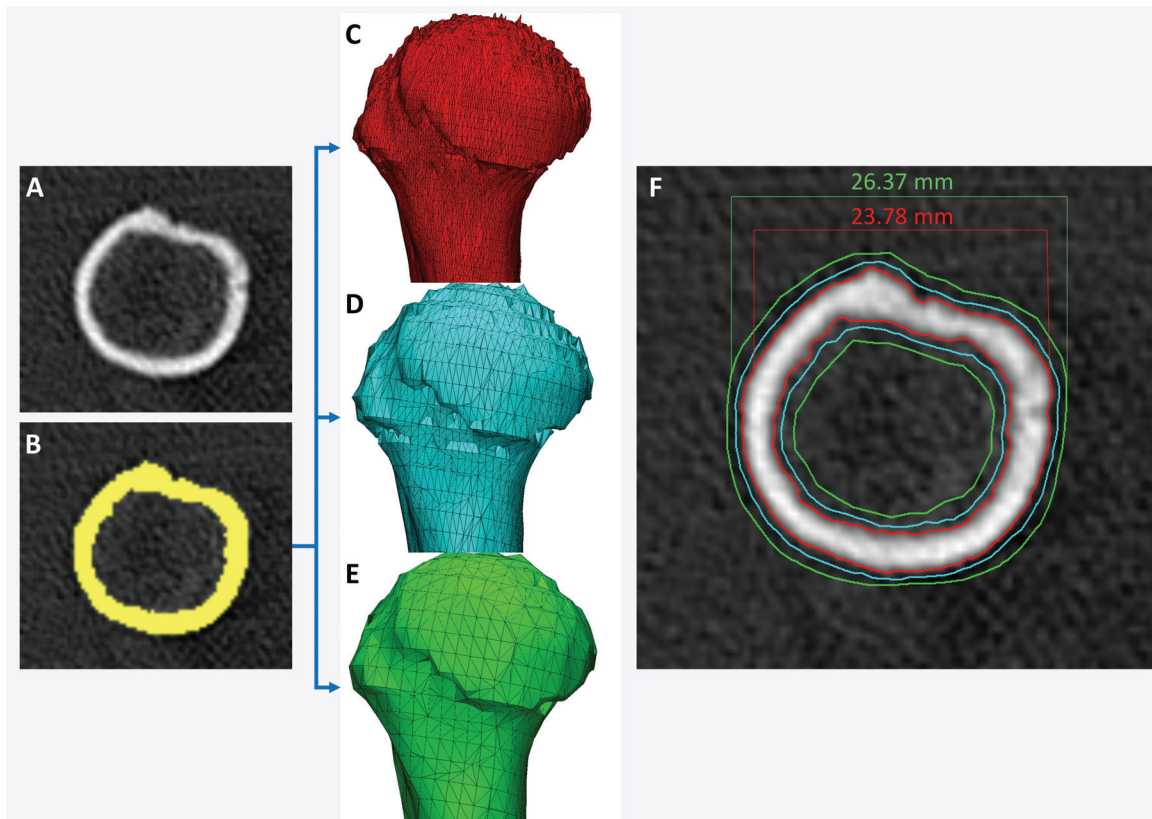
Differences in models based on different parameters used to generate the STL model from a segmentation. *A, B*, Axial CT image of a humerus, *A*, segmented with a 400-HU attenuation threshold, *B*, yields three STL models created by using different setting options (optimal, *C*; medium, *D*; and low, *E*) with use of one software (Mimics 18.0; Materialise NV). *C-F*, Differences among the models are seen in terms of triangle counts, *C-E*, and are nearly 3 mm in size, *F*.
